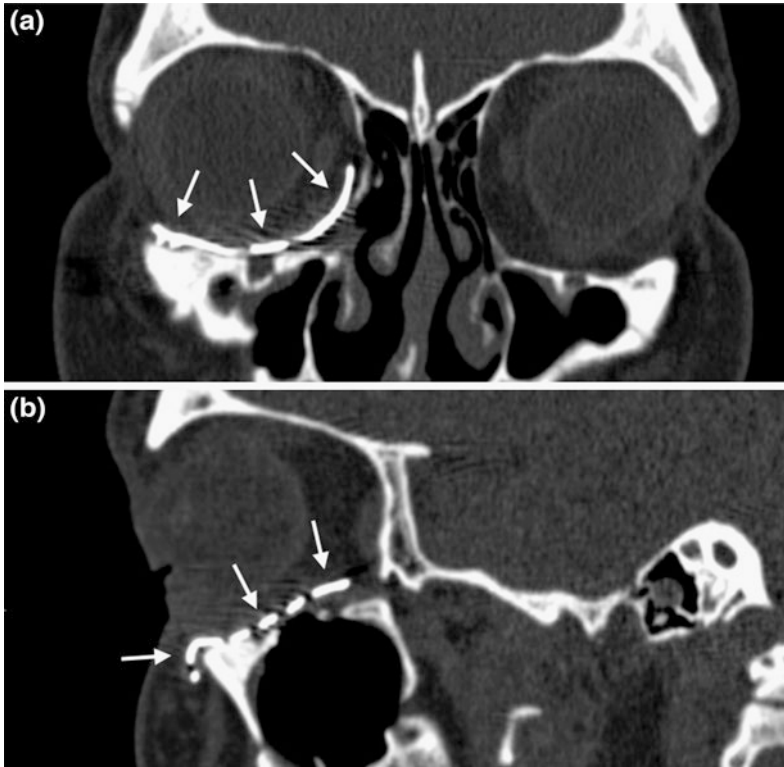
CT coronal (a) and sagittal (b) views of a titanium mesh implant that was molded to fit the shape of defect in concurrent orbital floor and medial wall fractures (arrows)
